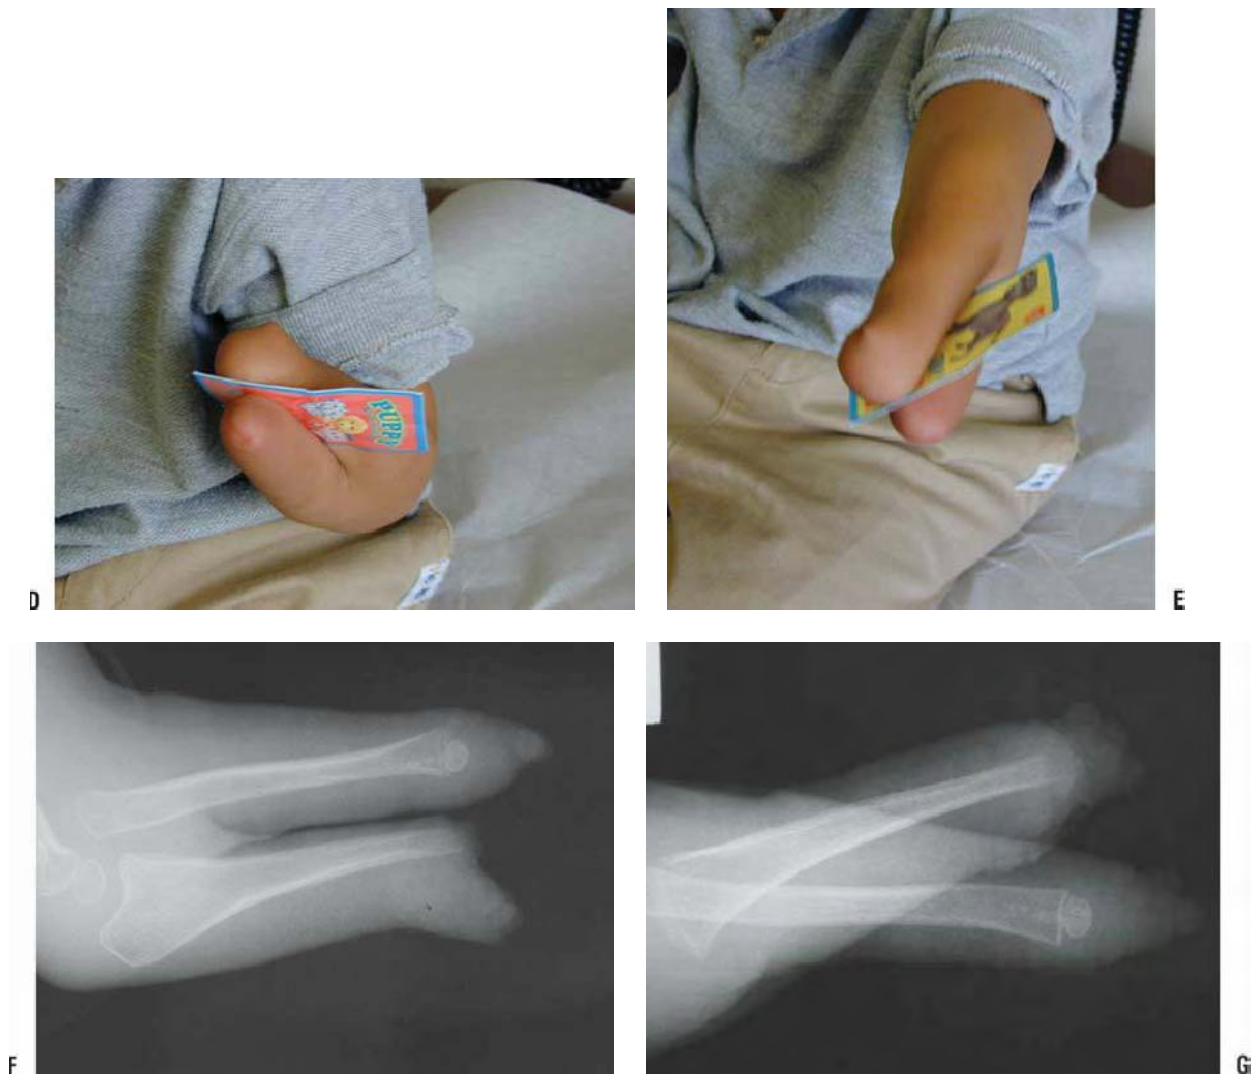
(Continued) D,E: Postoperative photographs of the patient demonstrating pincer grasp of a playing card. F,G: Forearm radiographs of the same patient taken in supination and pronation. The patient opposes the tips of the residual limb with pronation. Note the dislocated radial head seen in supination. Occasionally, this can become symptomatic.
